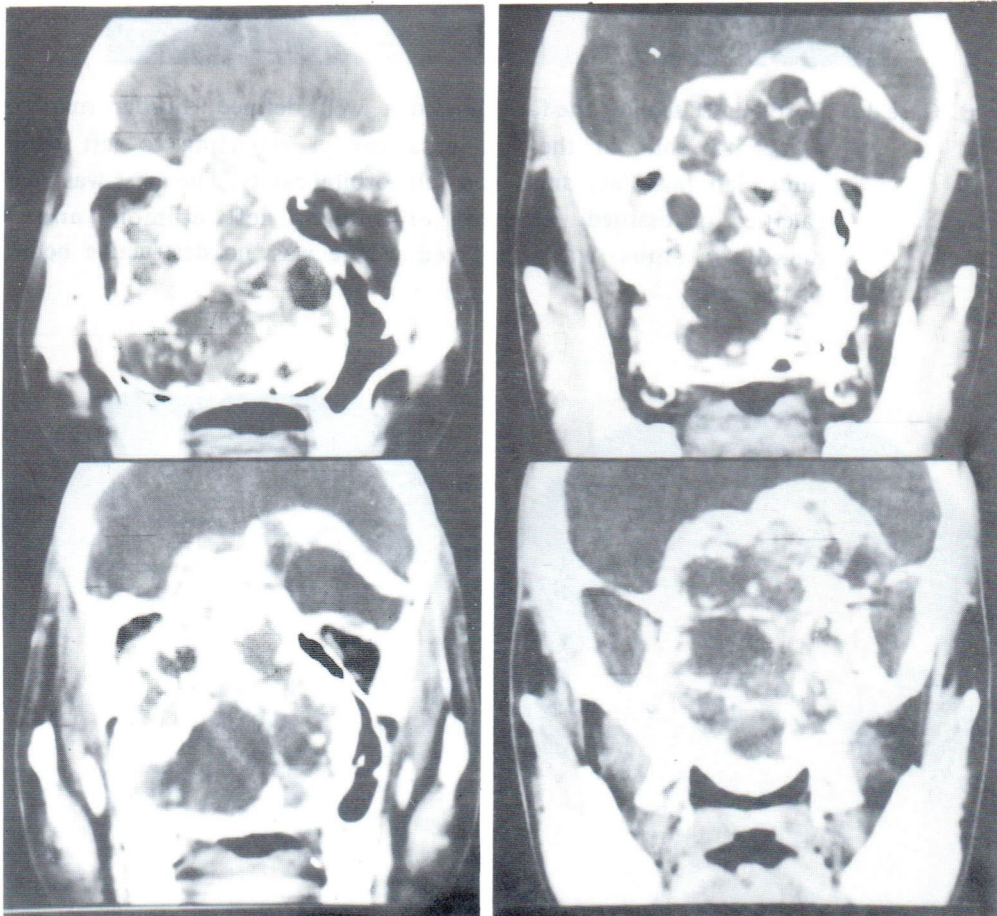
Case 2. I.V. enhanced coronal CT scan of the brain and face portion showed a large calcified or ossified mass in the nasal cavities, both maxillary sinuses, both orbital cavities, sphenoid sinuses, pituitary fossa, suprasellar cistern, anterior and middle cranial fossae. The mass was less dense than the mass of the case 1. There was as aggressive behavior, judging from the destruction of the involved bones.
